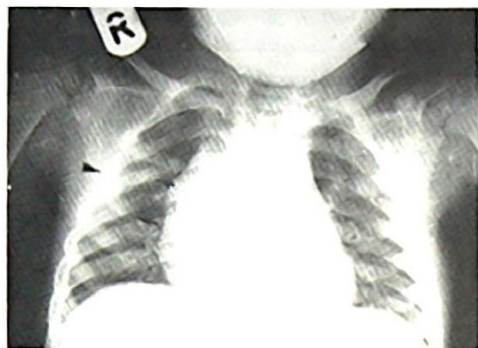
Postero-anterior chest radiograph of 3-year-old boy with bifid anterior third rib (\blacktriangle). Expanded rib before bifurcation (\blacklozenge).
